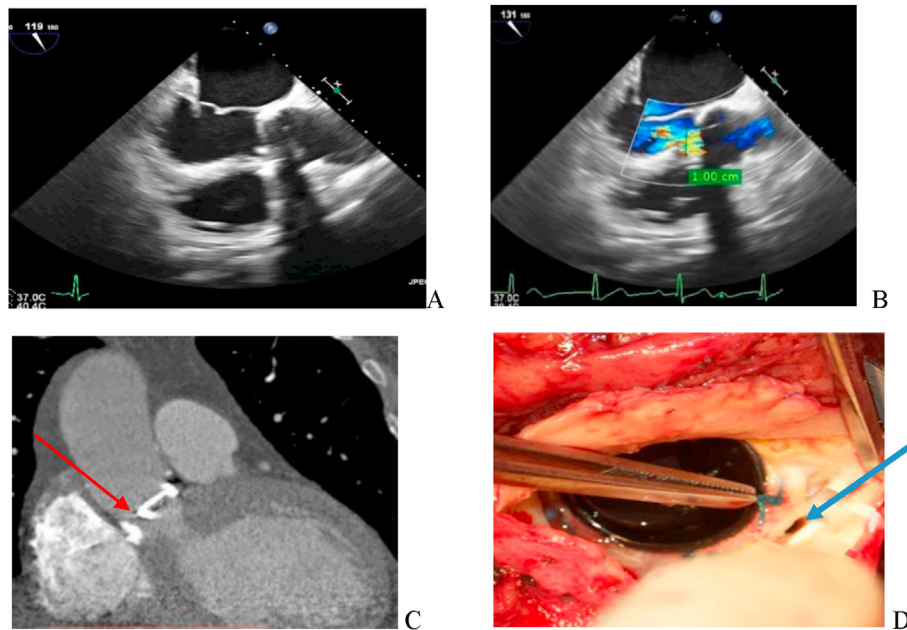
CT and TEE in a patient with suspected paravalvular leak and heart failure symptoms (A, B): TEE, mid esophageal, long axis view, showing paravalvular regurgitation related to posterior aspect of aortic mechanical prosthesis with jet width measuring 1 cm and occupies 50% of LVOT. (C): MCTA, coronal cut, long axis view showing aortic prosthetic PVL with severe calcifications (red arrow) related to PVL defect cause of defect not apparent by TEE. (D) is a surgical image showing aortic prosthesis PVL defect for the same patient (blue arrow).
